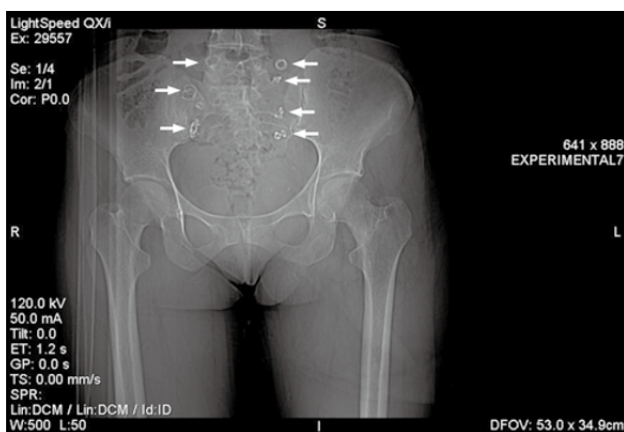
Preoperative scout film of computed tomography scan showing coils in bilateral ovarian veins.
